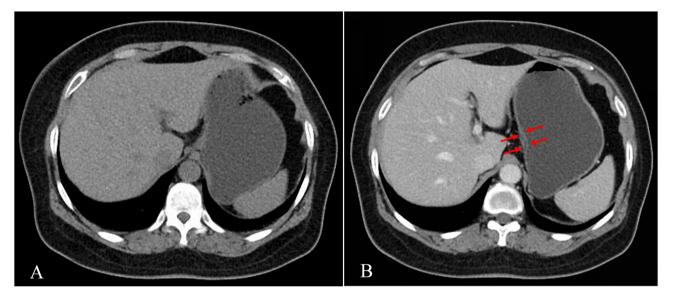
A typical case (male, 60 years old) with double-track sign (T1a stage, adenocarcinoma, moderately differentiated). (A) Plain CT image: No evidence of gastric abnormalities in the upper 1/3 of the stomach. (B) Enhanced CT image: The upper 1/3 of the stomach had a double-track sign (red arrows).
